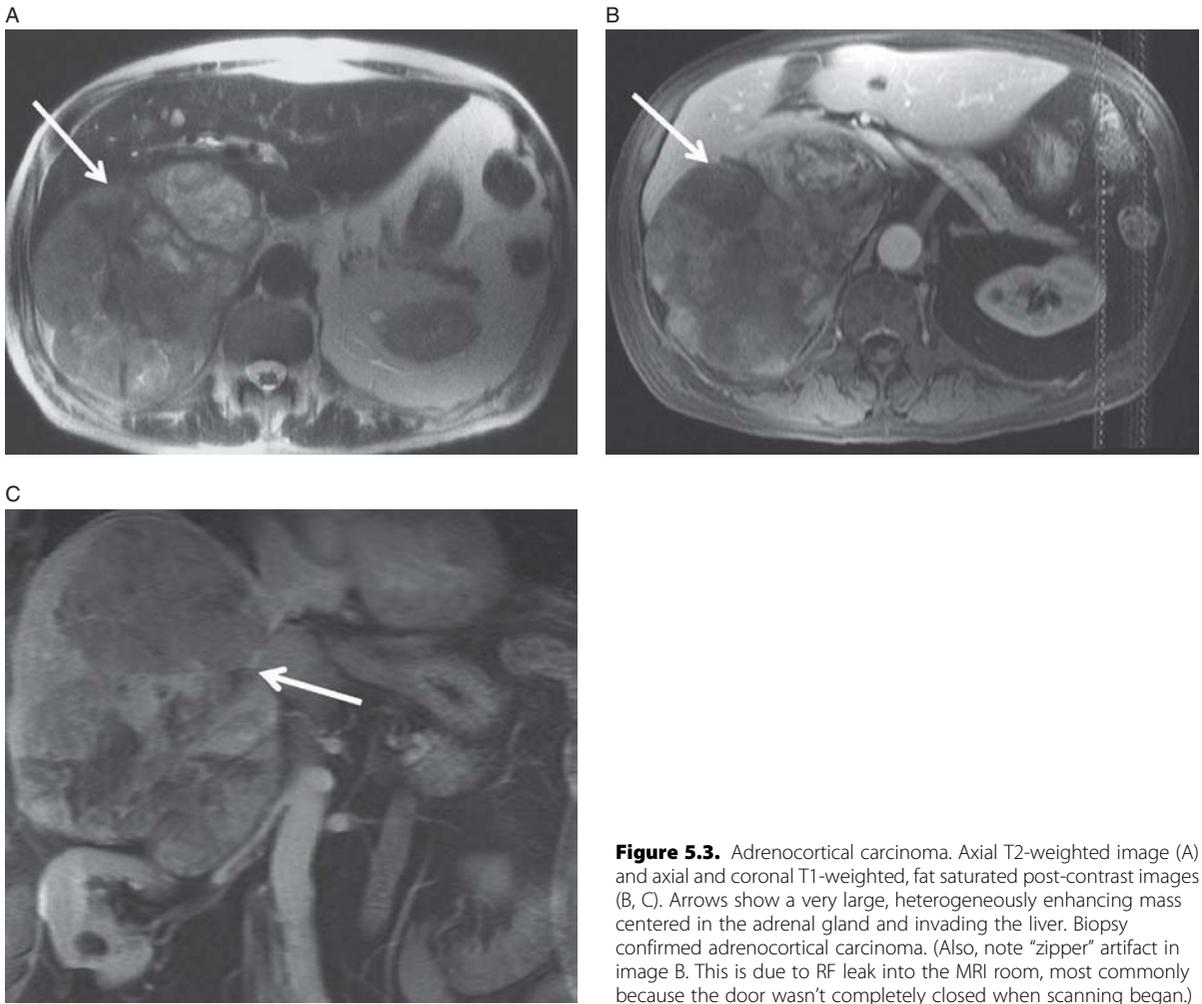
Adrenocortical carcinoma. Axial T2-weighted image (A) and axial and coronal T1-weighted, fat saturated post-contrast images (B, C). Arrows show a very large, heterogeneously enhancing mass centered in the adrenal gland and invading the liver. Biopsy confirmed adrenocortical carcinoma. (Also, note "zipper" artifact in image B. This is due to RF leak into the MRI room, most commonly because the door wasn't completely closed when scanning began.)
